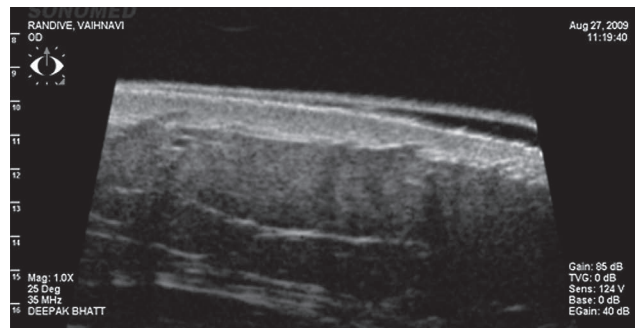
Normal sonography skin showing epidermal entrance echo and dermal thickness (hyperechoic region).
